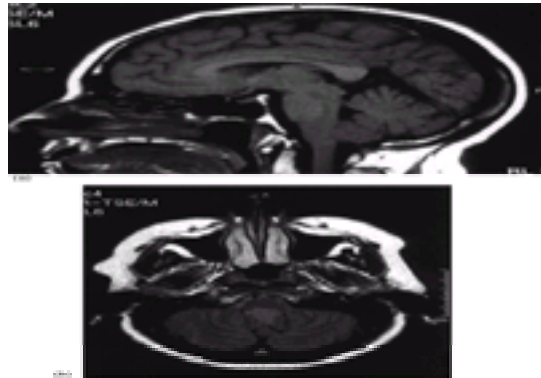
Subependymoma. (a) Sagittal T₁-weighted MRI demonstrating a mass at the caudal end of the fourth ventricle extending to the top of the cisterna magna with mild mass effect on the medulla and the inferior vermis. (b) Axial T₁-weighted gadolinium-enhanced MRI of a minimally enhancing lesion in the caudal fourth ventricle; note the relatively clear delineation of the tumor from the floor of the fourth ventricle.
